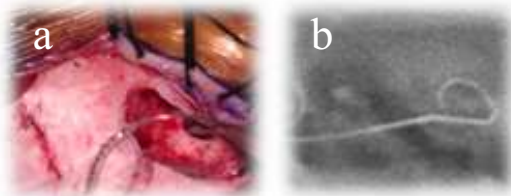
1: a) Cochlear Implant electrode insertion through PT technique, b) Post opt X-Ray of temporal bone: Cochlear Implant array in situ.
